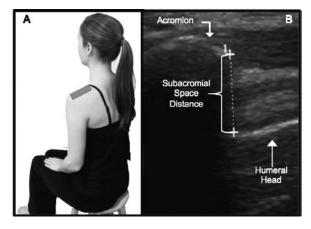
Measurement of subacromial-space distance. A, Participant positioning. B, Ultrasound measurement of subacromialspace distance.
